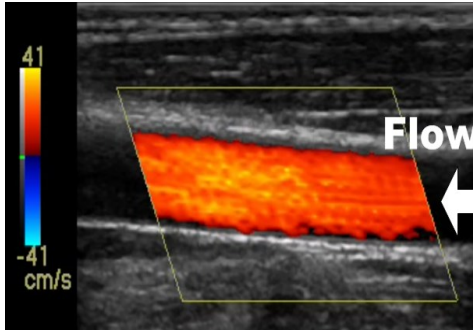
Color Doppler image of a carotid artery
